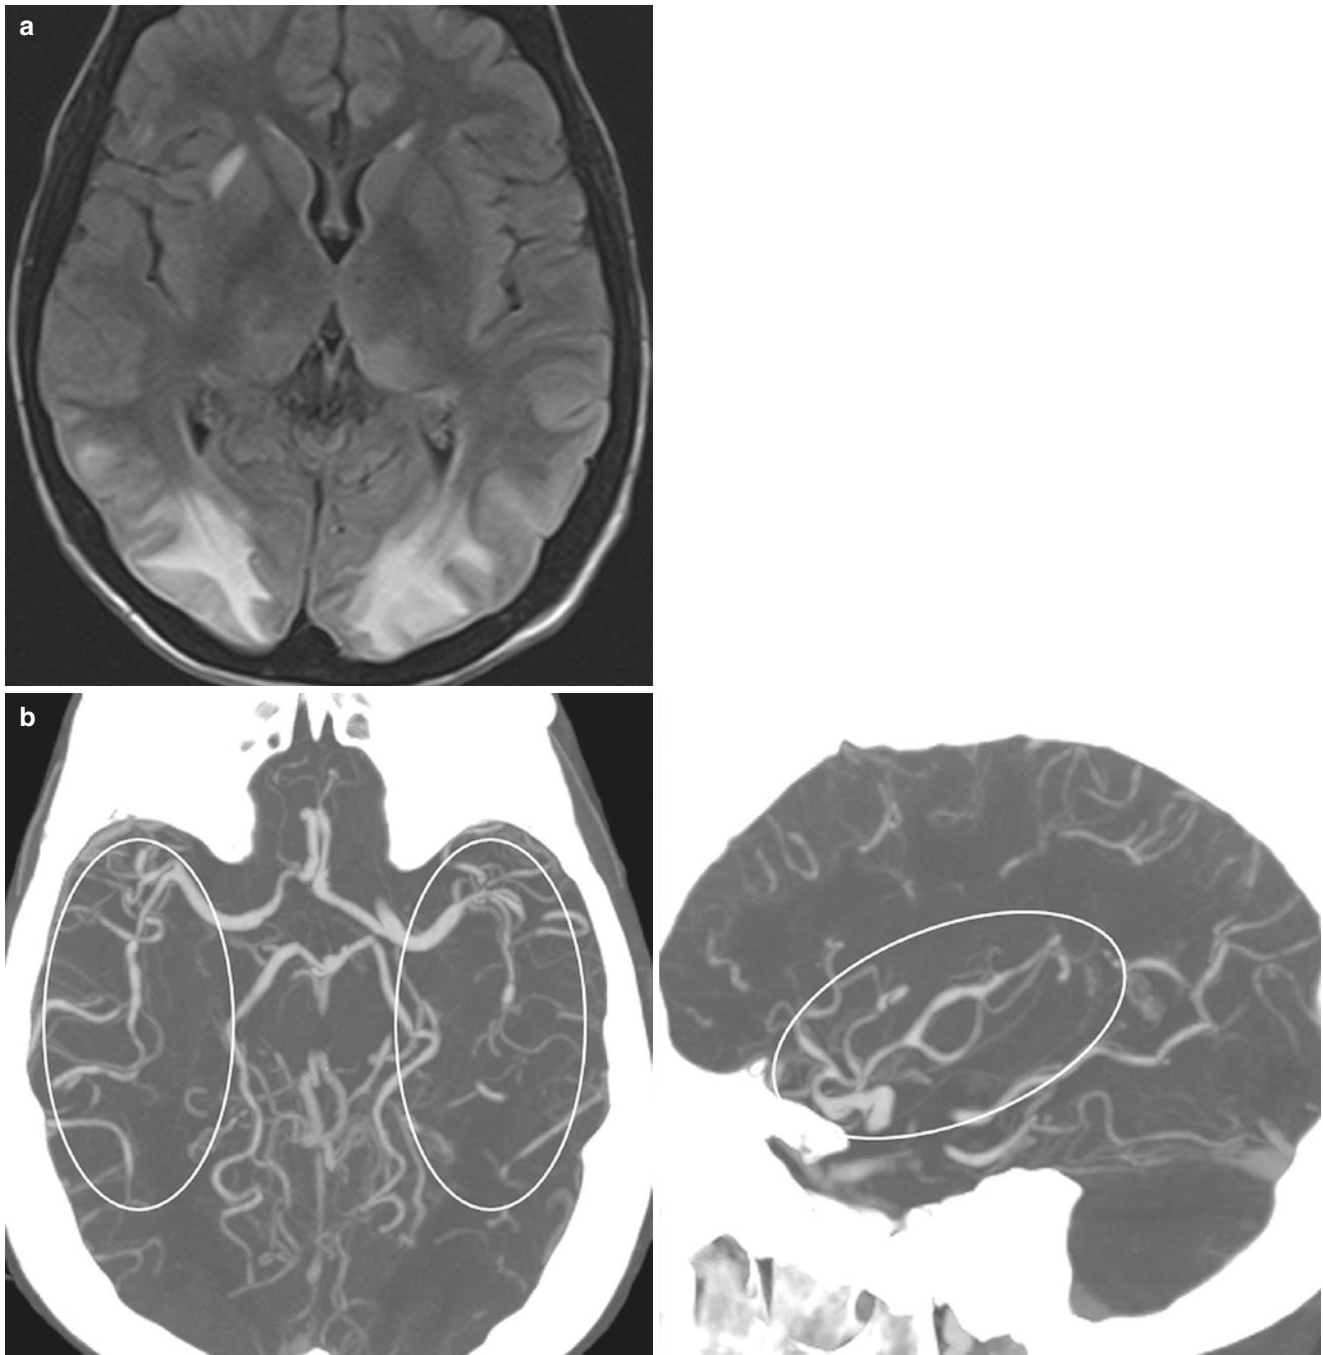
Posterior reversible encephalopathy syndrome. Patient with seizure and altered mental status. (a) Axial FLAIR shows symmetric vasogenic edema most prominent in the bilateral occipital lobes compatible with PRES type of pattern. (b) CTA head axial and sagittal reformations demonstrate multifocal contour irregularity and beaded
